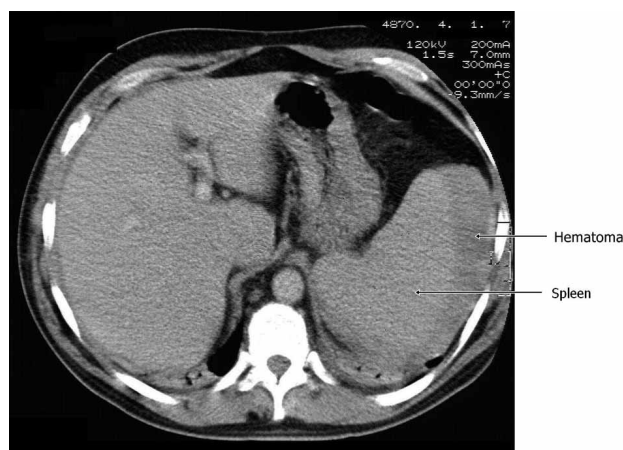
Abdominal CT scan demonstrating splenomegaly with a crescentic low-density fluid collection along the lateral margin of the spleen corresponding to subcapsular splenic hematoma.
